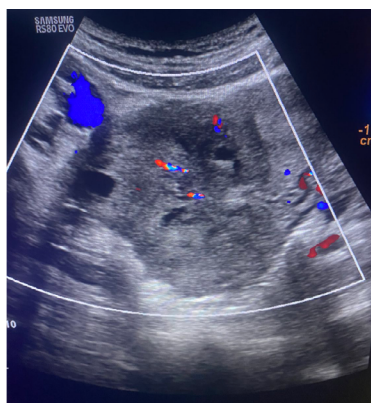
Doppler imaging of left ovary (Bulky left ovary which on color doppler study shows minimal central and peripheral vascularity)
